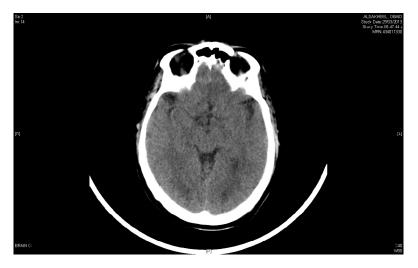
CT scan done in ER: Unremarkable scan, no grossly visible focus of seizures
